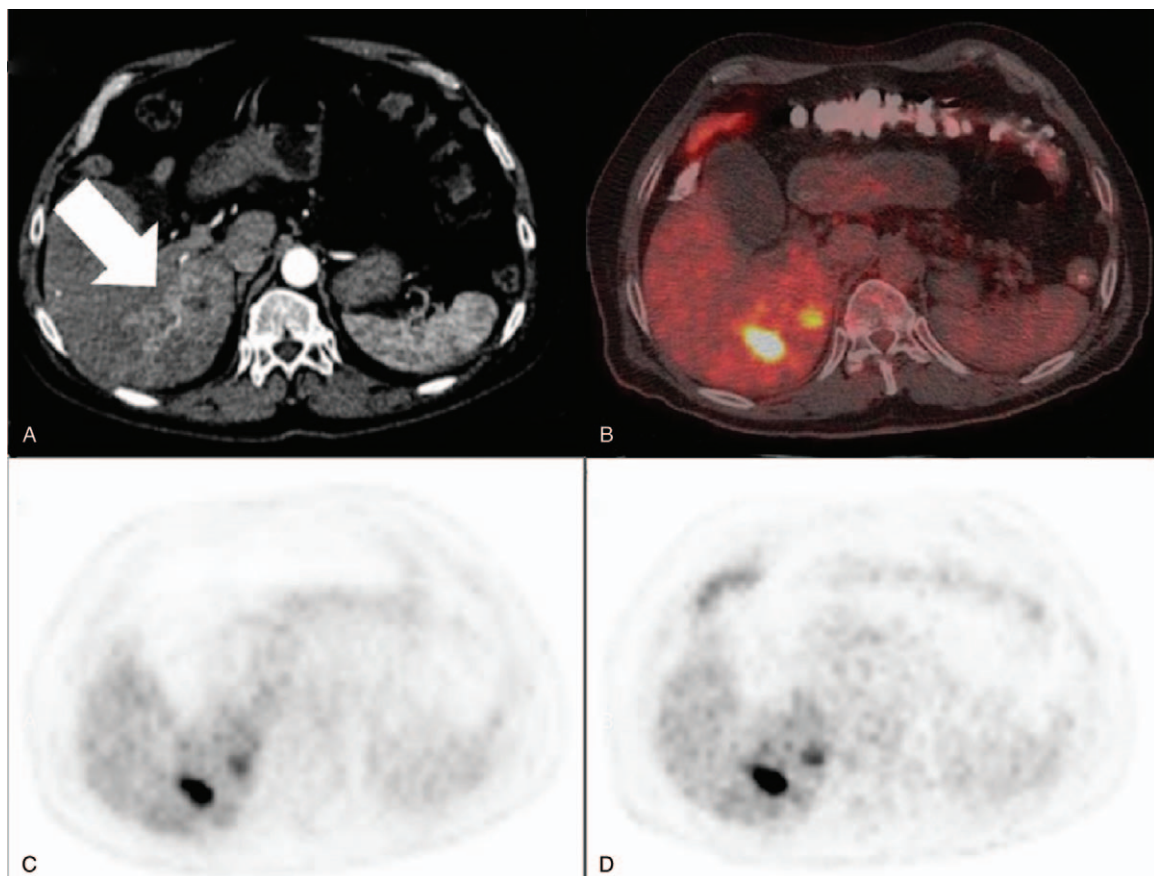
An example of a patient with distinct tumor uptake in which increased uptake is evident on delayed images. A, Hypervascular mass at the right lobe on contrast-enhanced computed tomography (CT). B–D, Higher tumor F-2-fluoro-2-deoxy-D-glucose (FDG) uptake at both delayed and early ^{18}F -FDG PET/CT images when compared to the liver parenchyma. Higher uptake is evident on the delayed image than the early image (SUVmax, 23.7 vs 17.8).
